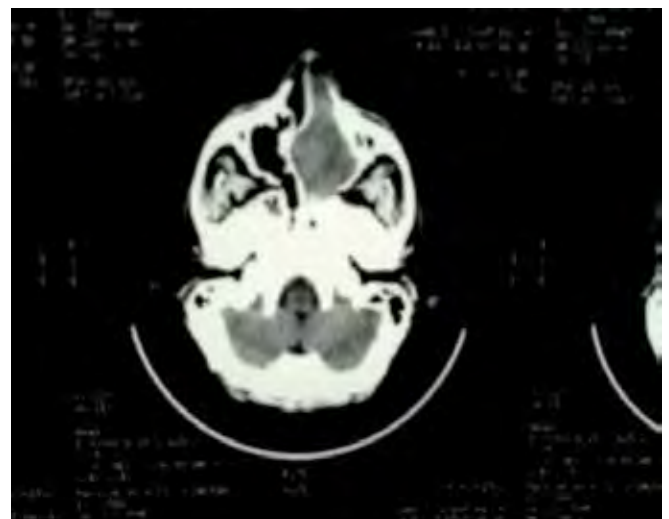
CT scan of Nose and Paranasal Sinuses
